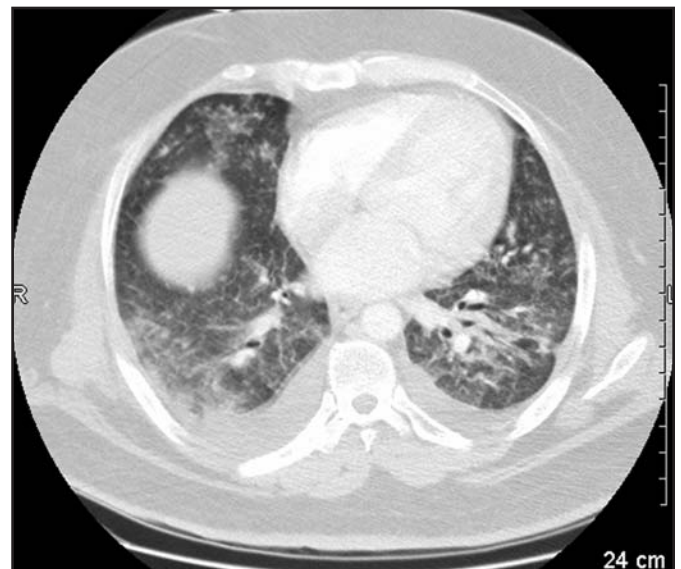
Computed tomography of the chest demonstrating bilateral pulmonary infiltrates without any pulmonary embolism
